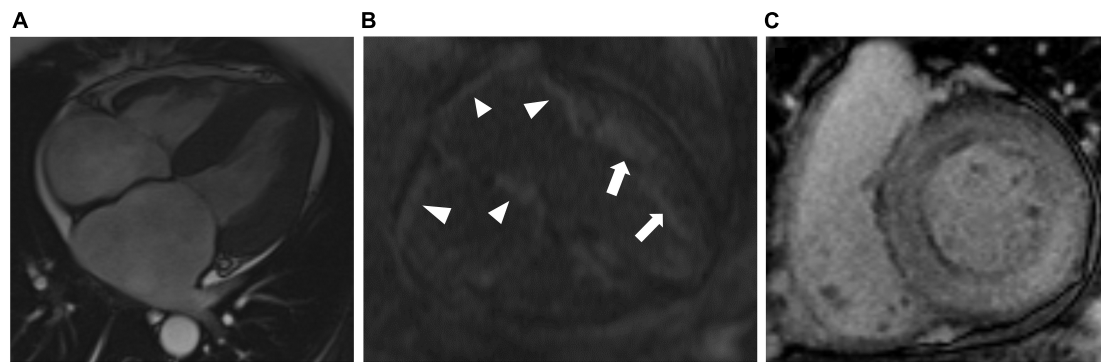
Representative cardiac magnetic resonance images (CMR) from patients with cardiac amyloidosis. (A) T2 TRUFI 4-chamber view showing biventricular hypertrophy, biatrial enlargement, and pericardial effusion. (B) T1 4-chamber view late post-contrast image in a patient with ATTR-CA showing diffuse atrial LGE (arrowheads) and left ventricular subendocardial LGE (arrows). (C) T1 short-axis late post-contrast image in a patient with AL-CA showing diffuse LGE of the left ventricle.
